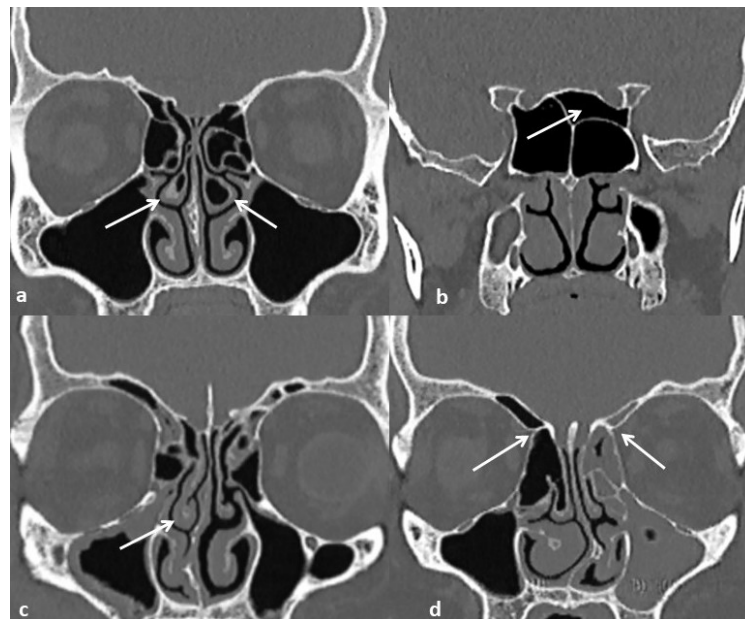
Coronal reformatted CT showing some common anatomical variants of the paranasal sinuses. (a) Bilateral conchae bullosae (arrows). (b) Onodi cell on the left side (arrow), in close relation to the left optic nerve. (c) Paradoxical curvature of middle turbinate on the right side (arrow). (d) Supraorbital pneumatization, exposing bilateral anterior ethmoid arteries (thin arrows). The ethmoid air cells on the left side are opacified.
